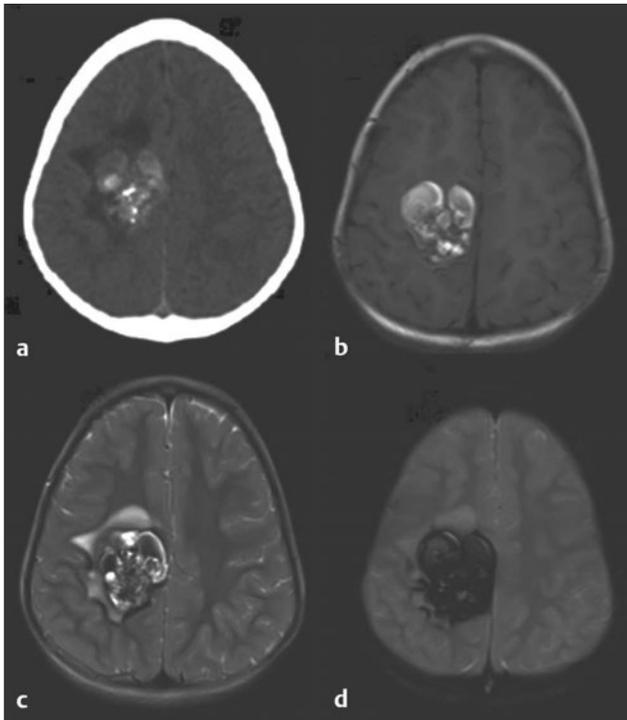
Cavernoma in a 4-year-old girl. (a) Computed tomographic scan of the head showing a mixed-density lesion with some blood and calcification. (b) Axial magnetic resonance (MR) image showing a T1 bright lesion with surrounding hematoma and the typical “popcorn-like” character. (c) Axial T2 MR image of the same lesion. (d) Gradient-echo MR imaging sequence demonstrating the blood product.
